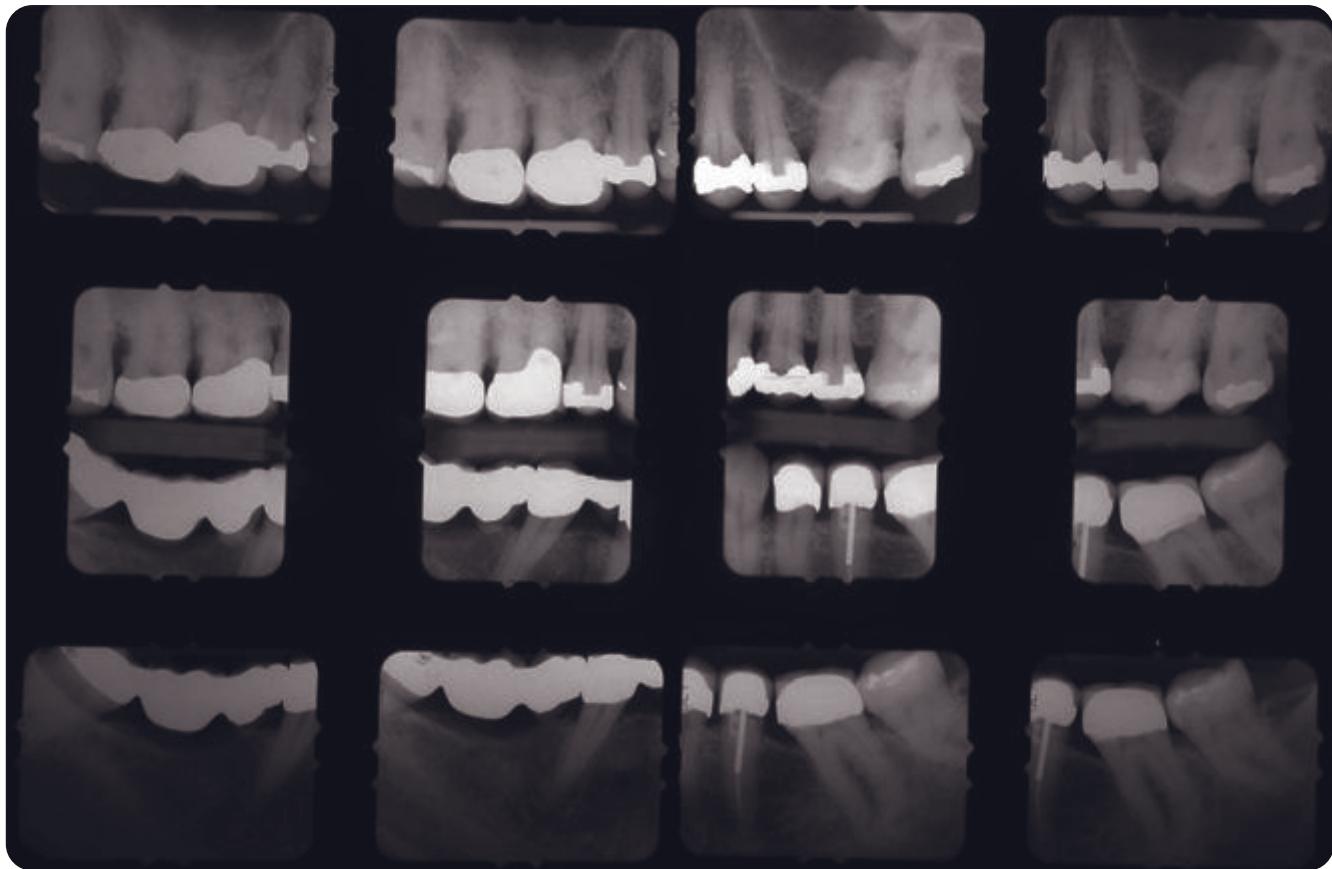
Pretreatment posterior radiographs. Note root proximity issues of maxillary right first molar. Structurally the mandibular teeth are maintainable.
